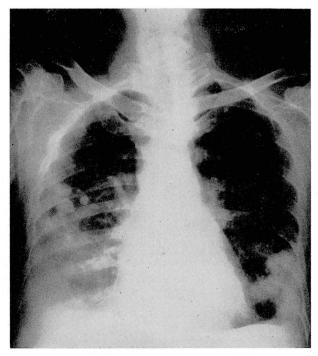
Roentgenogram of chest in 1955.
